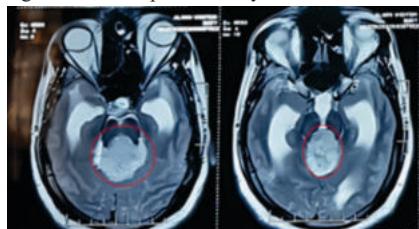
MRI of the Brain (axial plane) Showing Fourth Ventricular Ependymoma.
